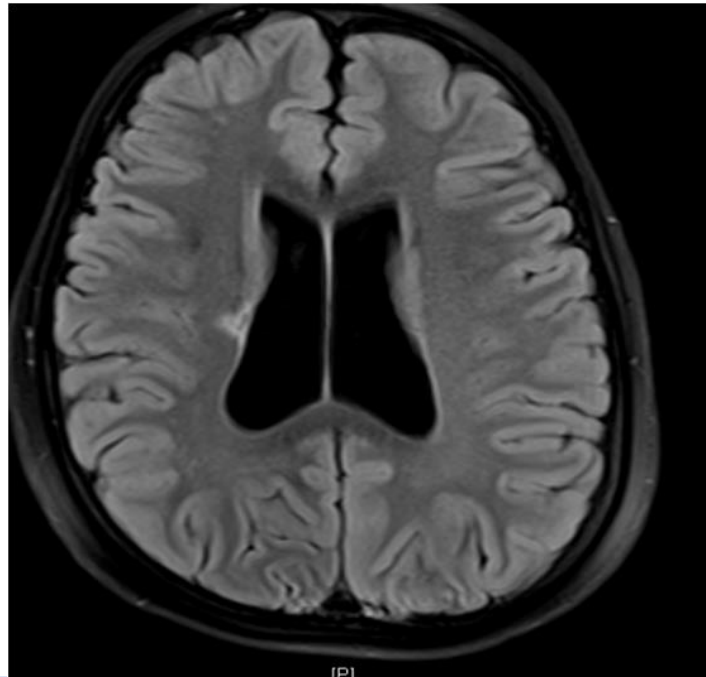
MRI brain showing focal areas of gliosis involving the right corona radiata and right centrum semi ovale.
